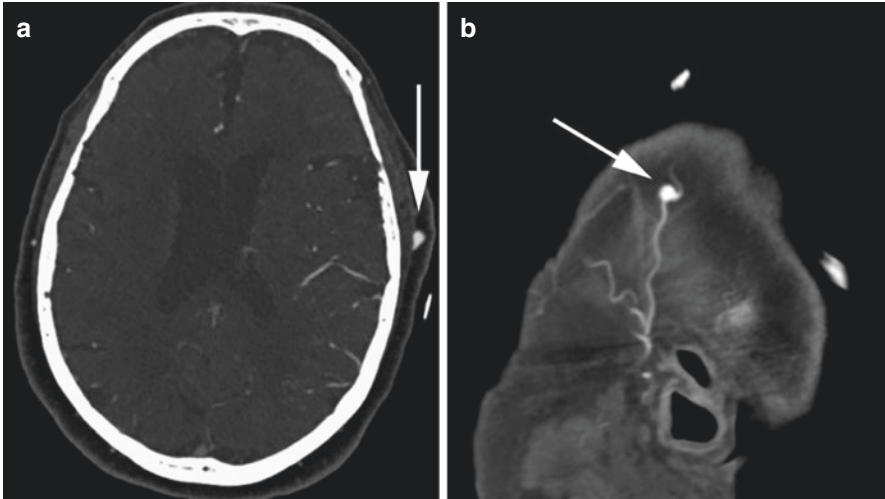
Superficial temporal artery vasculitis and pseudoaneurysm. Patient with headache and vision loss who underwent workup with CTA. Axial (a) and sagittal CTA images (b) showed a 5 mm left sided superficial temporal artery pseudoaneurysm and the patient subsequently went to biopsy confirming giant cell arteritis
